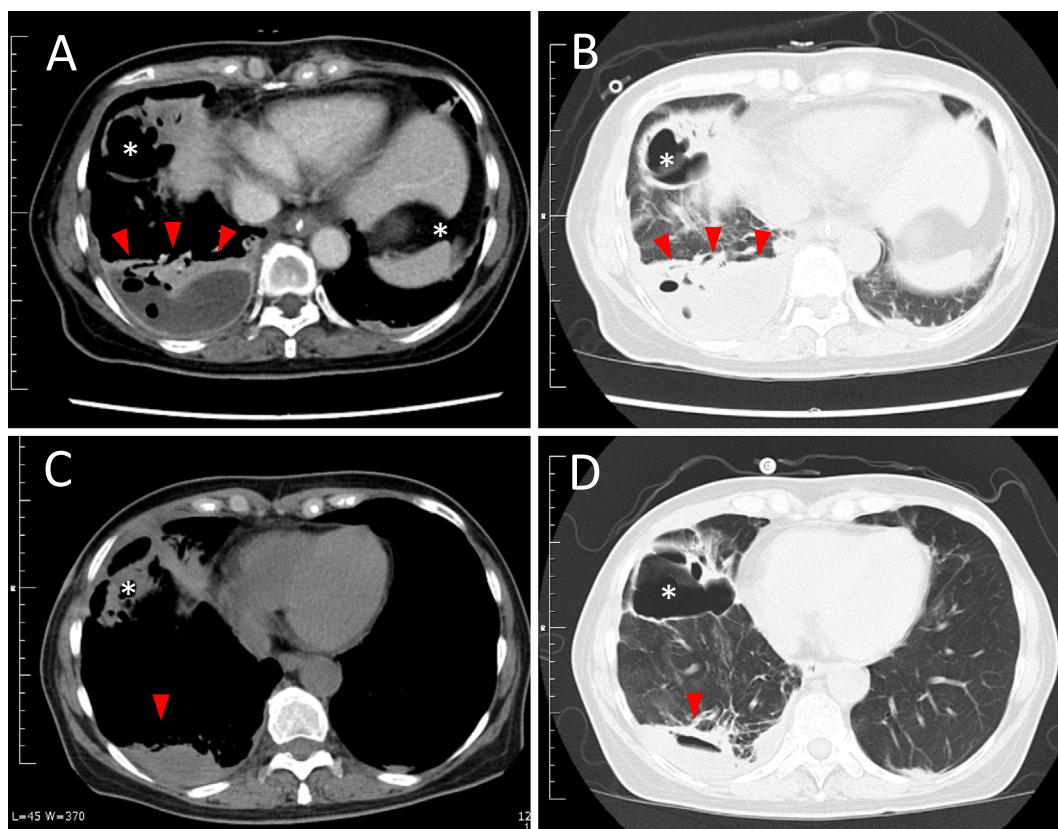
CT images before and after the treatment of *Klebsiella pneumonia*. (A, B) CT images taken on the eighth hospitalization day. A new consolidation, an abscess (red arrows), and porosis (asterisks) were all found in the right lower lobe, suggesting the development of *Klebsiella pneumonia*. (C, D) CT images taken after treatment with meropenem and ceftriaxone on the 39th hospitalization day. CT: computed tomography
